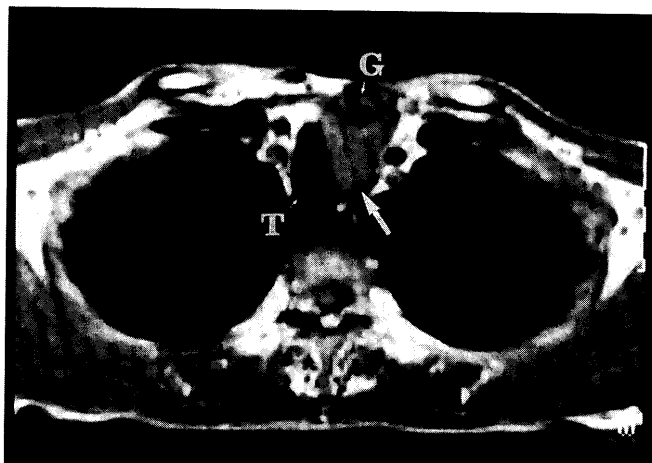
MRI showing a metastatic tumor (*arrow*) at the left side of the trachea. T and G indicate the trachea and gastric tube, respectively.
